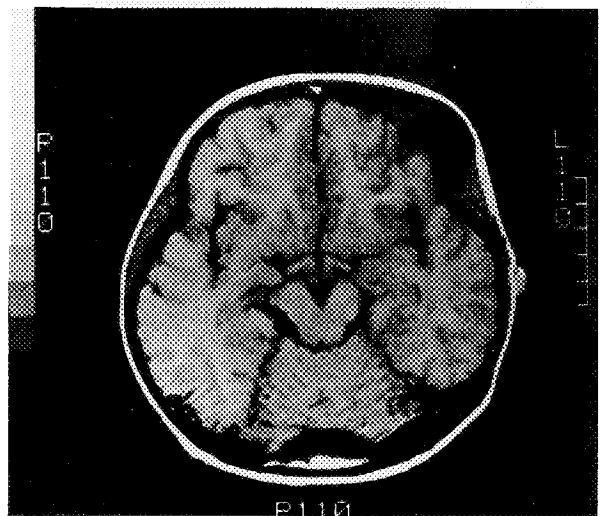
T1-weighted image of Patient 2. Affected bone shows low signal intensity.
